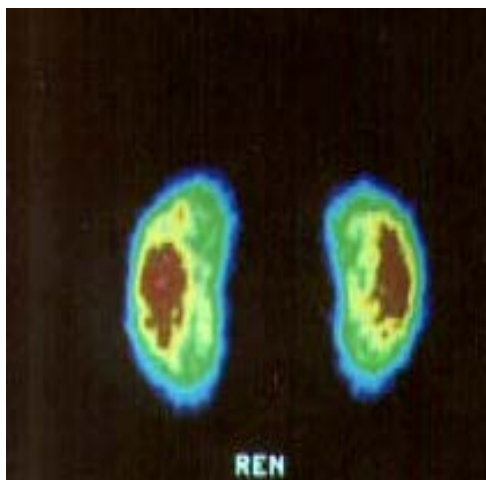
Static renal scintigraphy of kidneys with ^{99m}Tc - DMSA. Accumulation ^{99m}Tc -DMSA by both kidneys intensive enough and uniform. Both kidneys of the usual form, the sizes and a position. Norm
